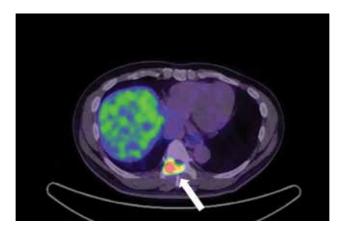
The PSMA PET scan demonstrates uptake of the tracer in a spine at the T9 level denoted by the white arrow.
